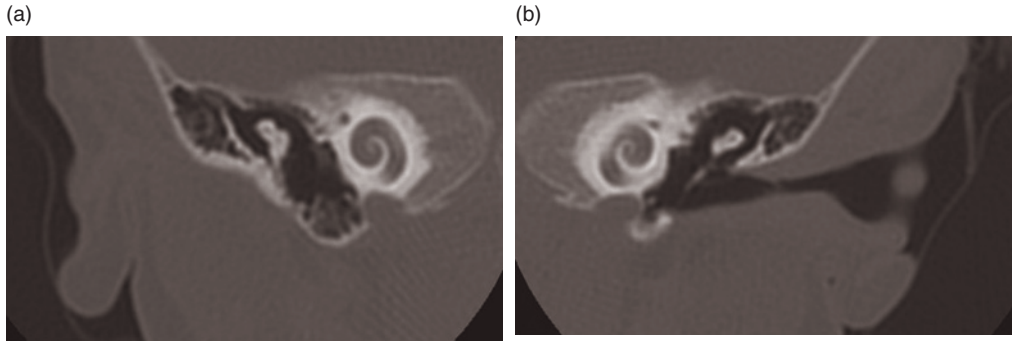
Coronal CT scans. Right atresia (a); normal left external auditory canal (b) (reproduced from Calzolari F., 2006,⁶ with permission of Omega Edizioni).
